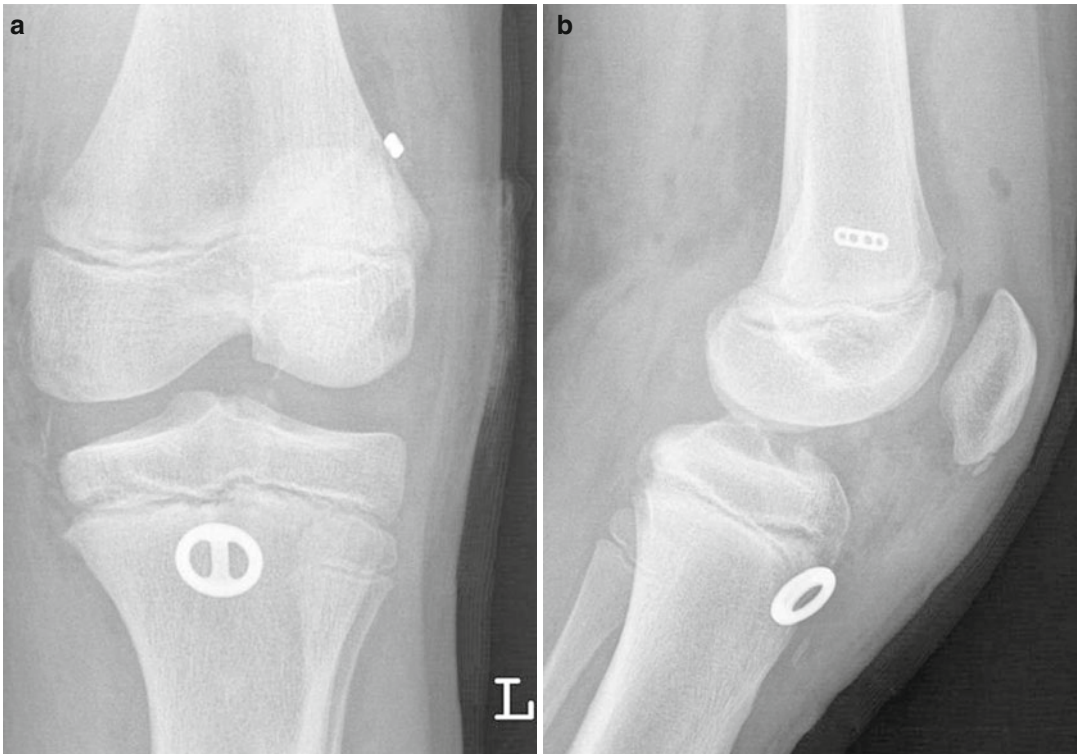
(a, b) Postoperative x-rays
